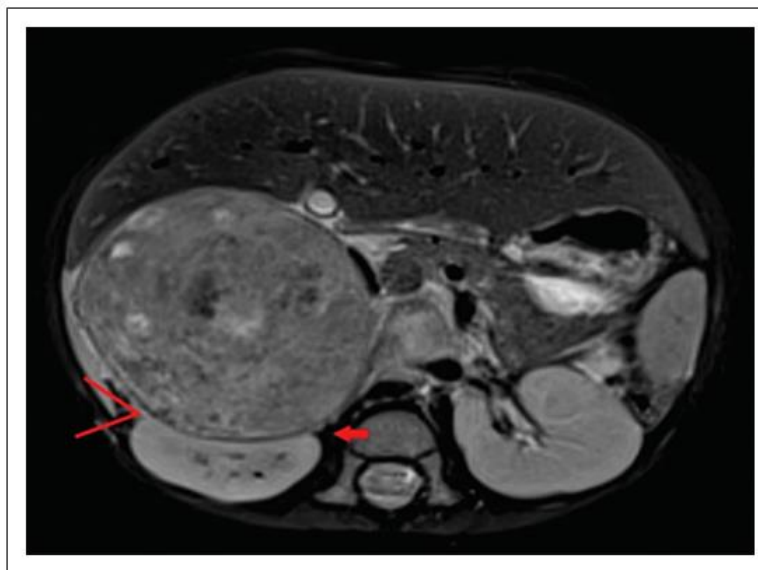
Axial fat-suppressed T2-weighted magnetic resonance image of a neuroblastoma compressing the right kidney. The claw sign is negative with absent tapering, infolding (red arrow) and acute external kidney–tumour interface.
